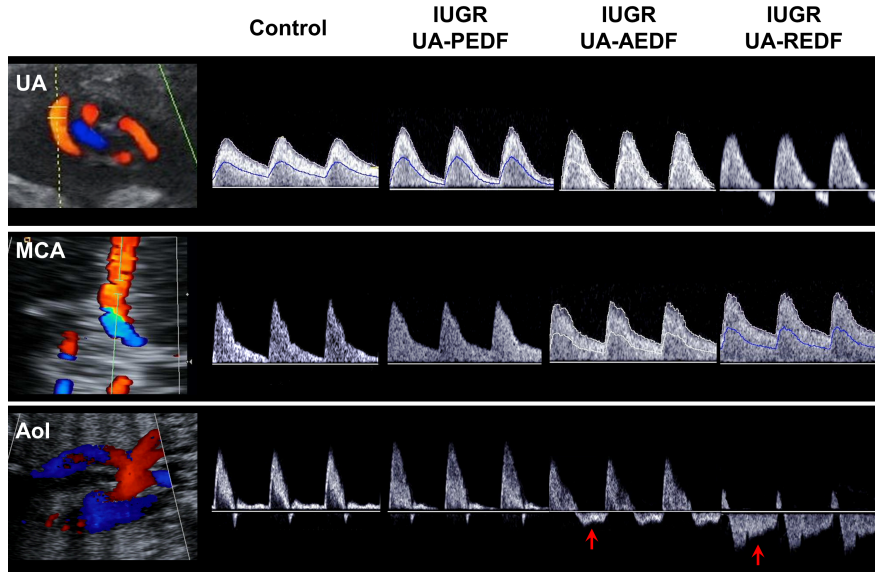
Doppler recordings from umbilical artery (UA) (top), middle cerebral artery (MCA) (middle) and aortic isthmus (AoI) (bottom) for the control and the three intrauterine growth restricted (IUGR) fetuses with present (PEDF), absent (AEDF) or reverse (REDF) umbilical artery end-diastolic flow. Red arrows indicated reversal flow in the AoI.
